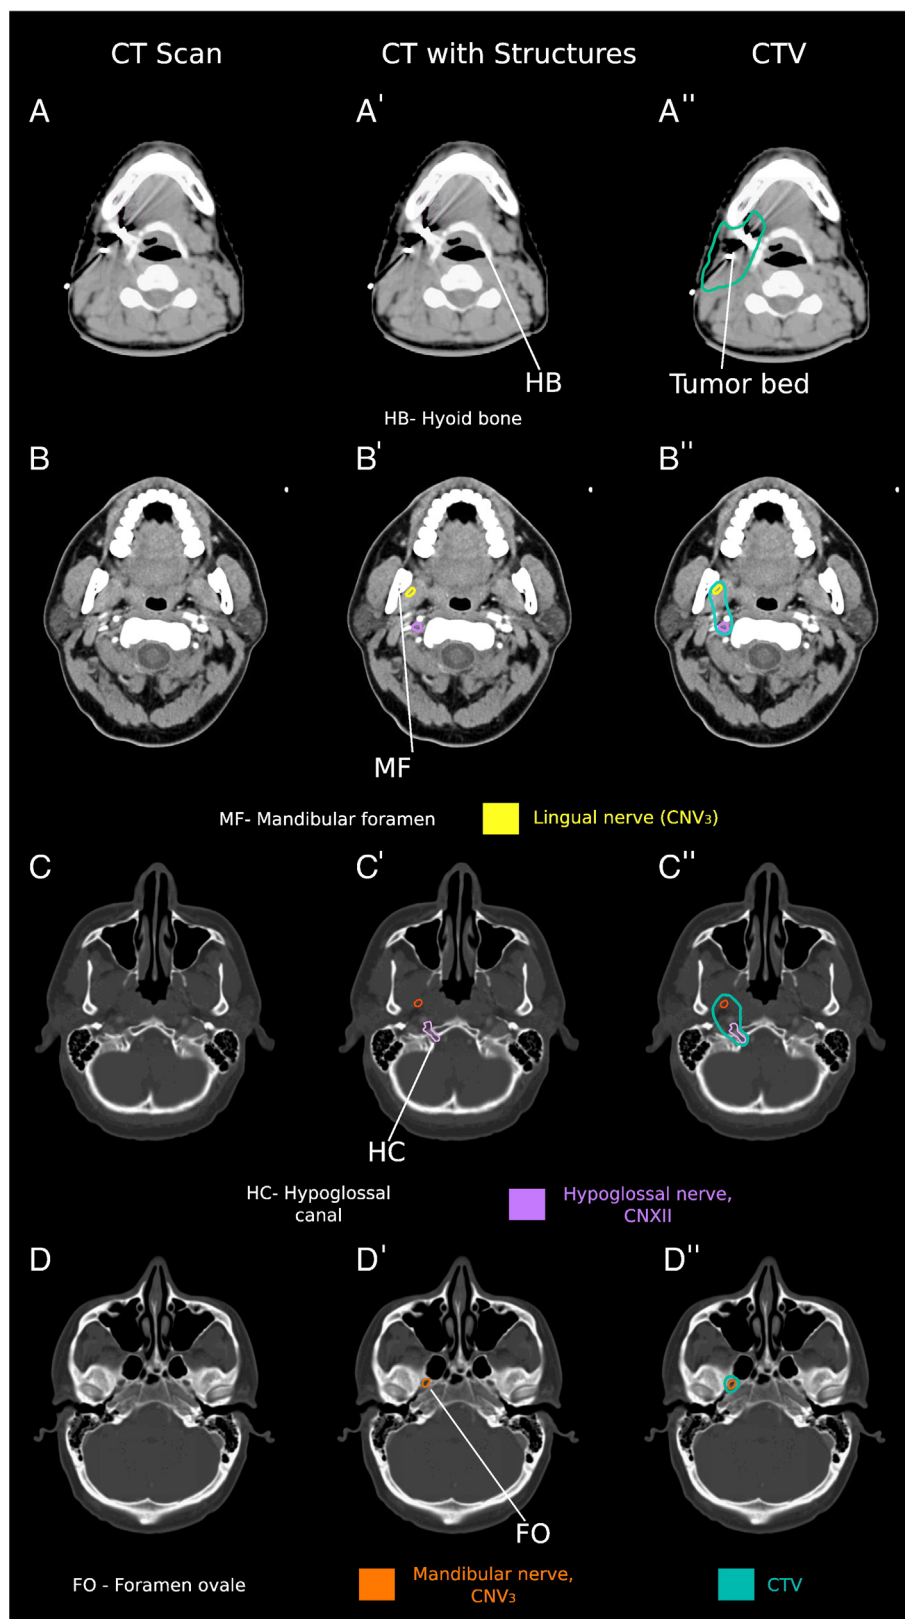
Axial computed tomographic (CT) slices of the submandibular gland and related cranial nerves (CN). The left column (A-D) depicts axial CT images of the area of interest, the middle column (A'-D') depicts the nerves contoured on CT images, and the right (A''-D'') depicts these contours with a clinical target volume (CTV; shown in teal). The mandibular nerve (CN V₃) (shown in orange), and its branch, the lingual nerve (shown in yellow), provide innervation to the submandibular gland and are at risk for harboring cancer in the setting of perineural invasion. The hypoglossal nerve (CN XII) (shown in purple) can also be involved in cancers of the deep lobe of the submandibular gland.
